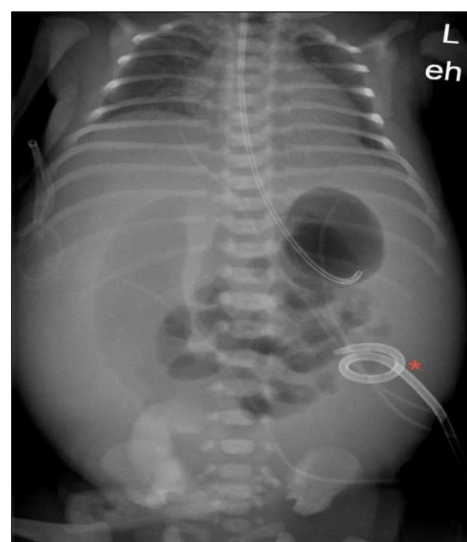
Abdominal radiograph with air-filled bowel loops and ascites despite drainage with pigtail catheter (*)
